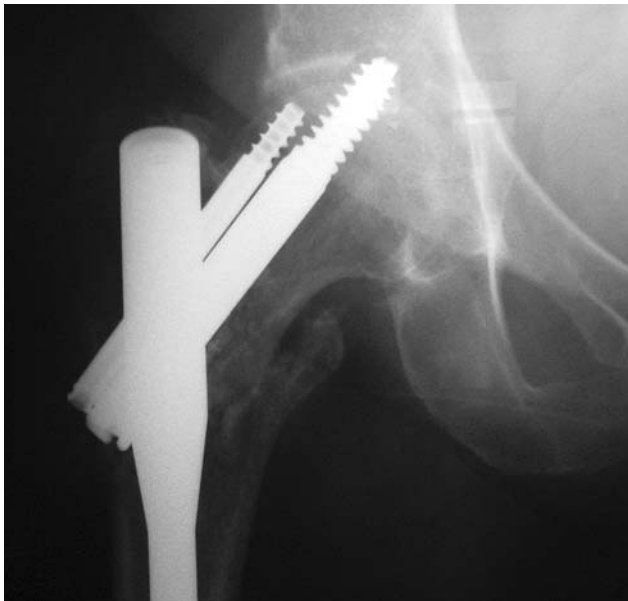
Post-operative radiograph of same hip showing superior migration of cannulated screw as PFN fails.
